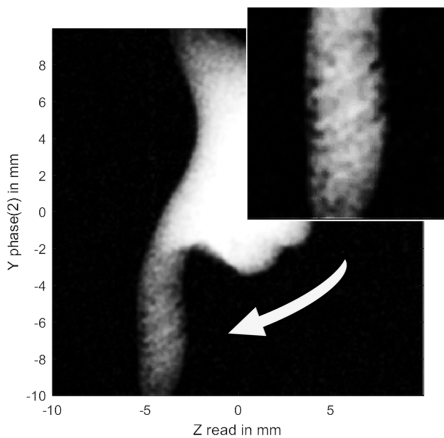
The coil location indicated with a white arrow in an MRI image, a further digital zoom in the top right corner.
